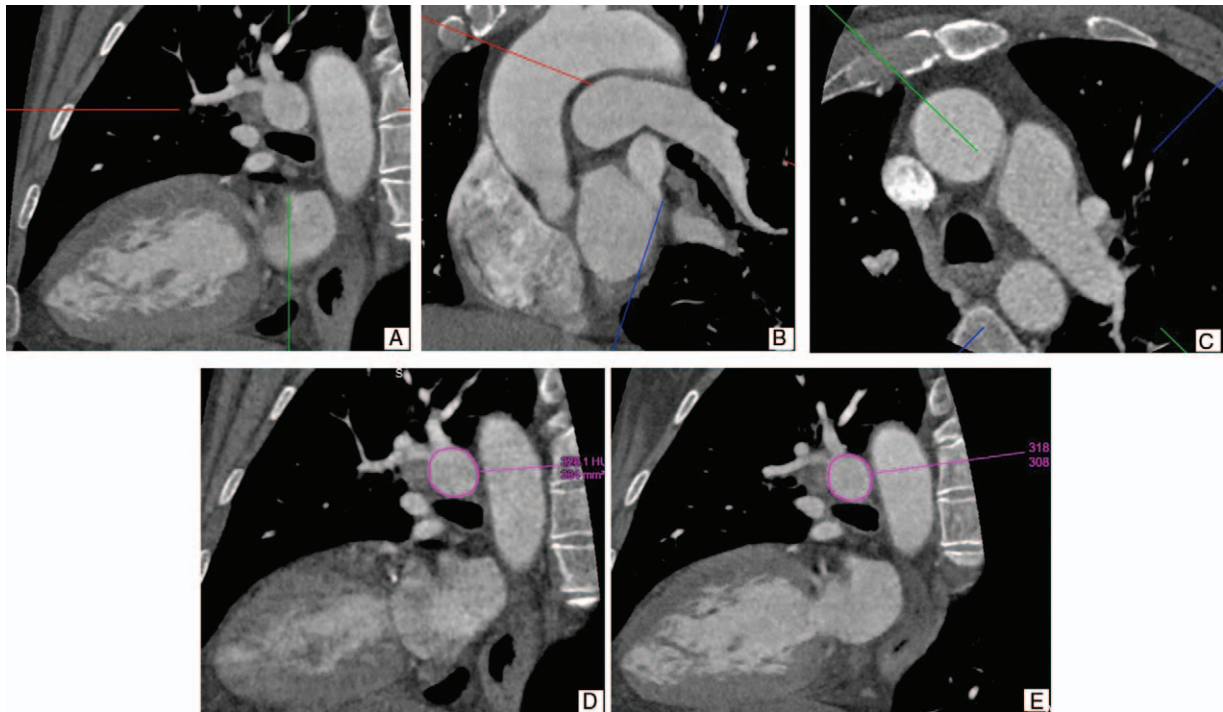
Computed tomography reconstruction plane for left pulmonary artery (LPA) cross-sectional area. (A) Sagittal reconstruction of LPA cross-section after correction for its double obliquity. The plane of reconstruction used for cross-sectional area measurement was adjusted to be perpendicular to the LPA on both (B) coronal and (C) axial views. The manual measurement method of LPA at (D) systolic and (E) diastolic.
